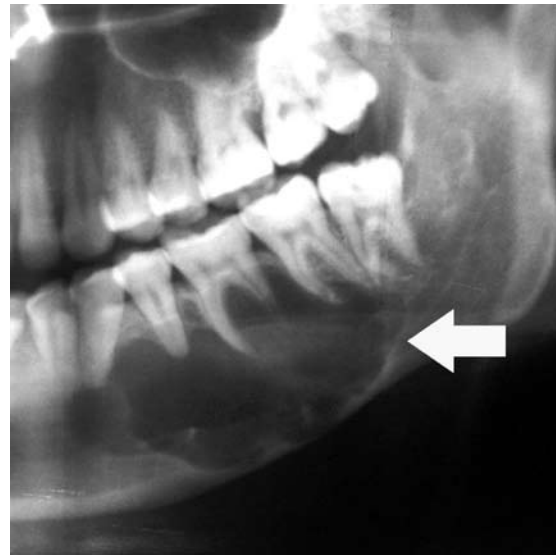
Primordial cyst. Panoramic radiograph shows a well-defined radiolucency in the location of the right third molar which has failed to develop (arrow).
